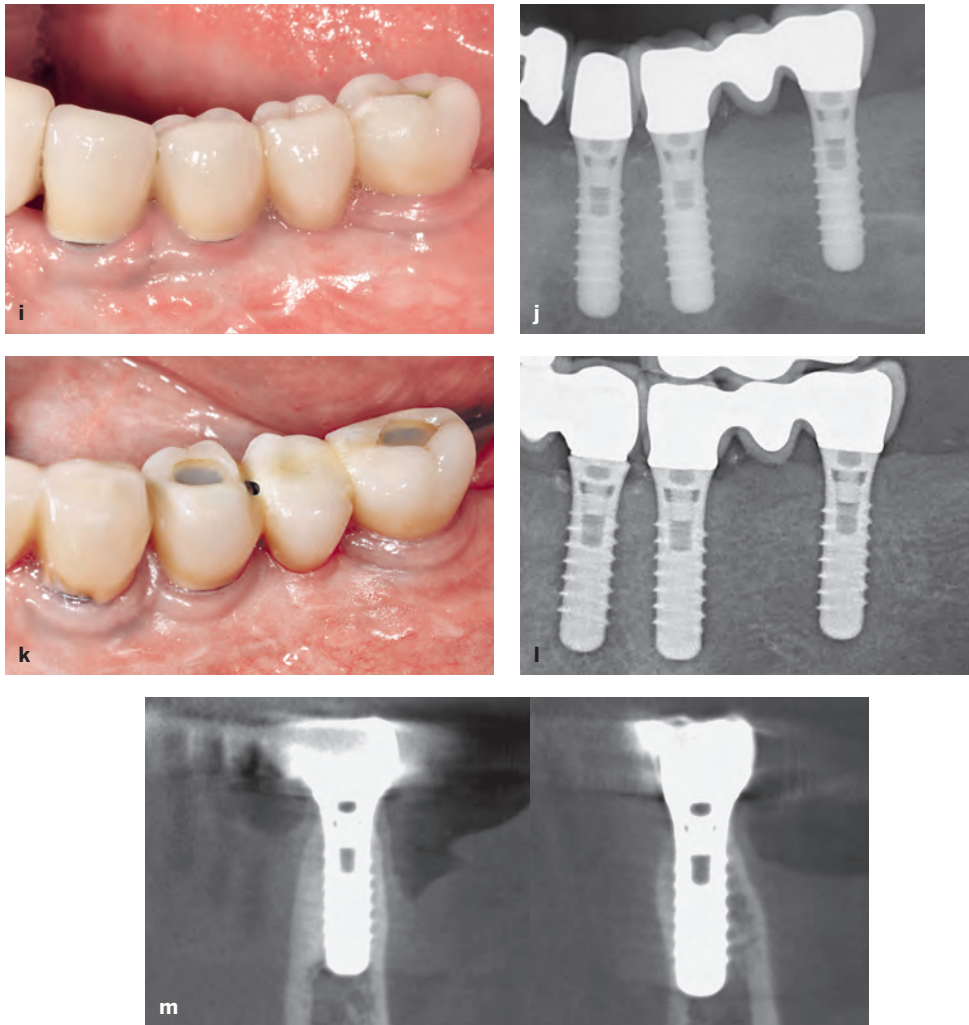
Case 3. (cont) (i) Clinical status at the 15-year examination. The peri-implant mucosa is stable but shows some signs of mucositis. (j) The radiograph confirms stable bone crest levels at all three tissue-level implants. (k) Clinical view at the 25-year follow-up examination (2019). The patient is now 85 years old, and the plaque control is no longer optimal. The mucosa around the tissue-level implants with a machined implant surface in the neck area shows very stable peri-implant tissues. (l) The periapical radiograph confirms stable bone crest levels at all three tissue-level implants after 25 years of function. (m) A CBCT scan is taken to examine the peri-implant bone volume. The orofacial cuts demonstrate fully intact buccal bone walls at the two implants in the first premolar and first molar sites, where a block graft augmentation with GBR was done in 1993.
